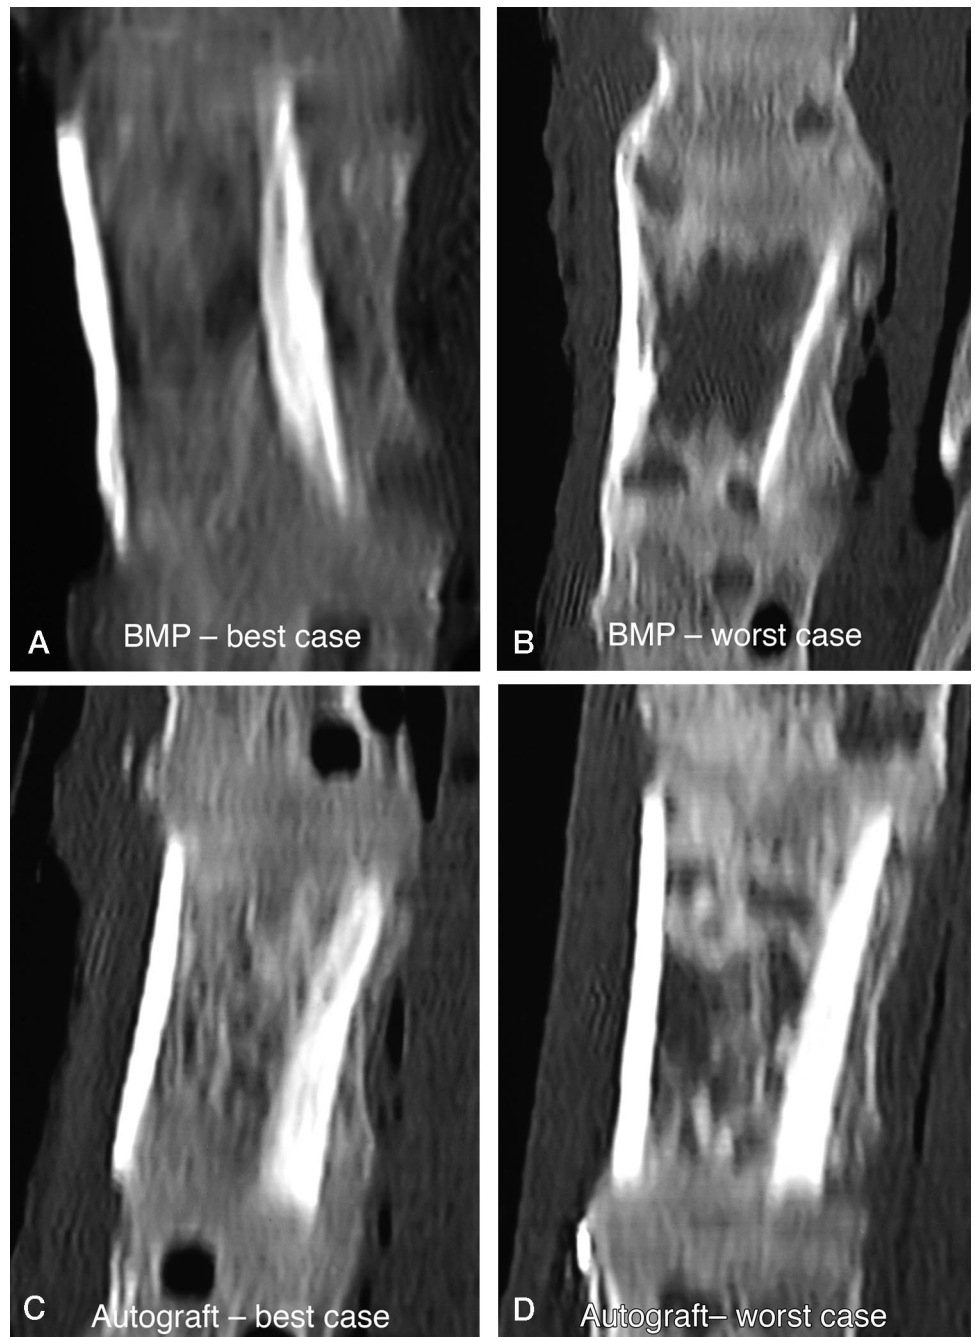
Midsagittal CT images of lumbar corpectomy site 4 months after surgery. Parts A and B are of grafts filled with *rhBMP-2* impregnated sponges. A, Best case. B, The case of least amount of bone formation within the strut allograft. Parts C and D are of autograft filled grafts. C, The “best” case. D, The “worst” case.
